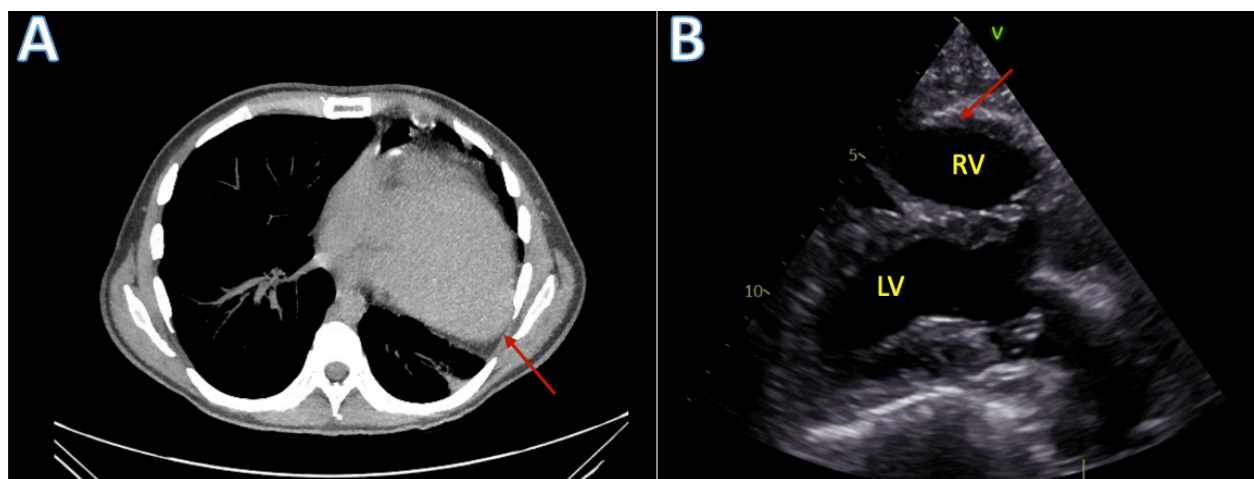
A - Chest CT demonstrating leftward cardiac displacement and absence of pericardium (red arrow).
